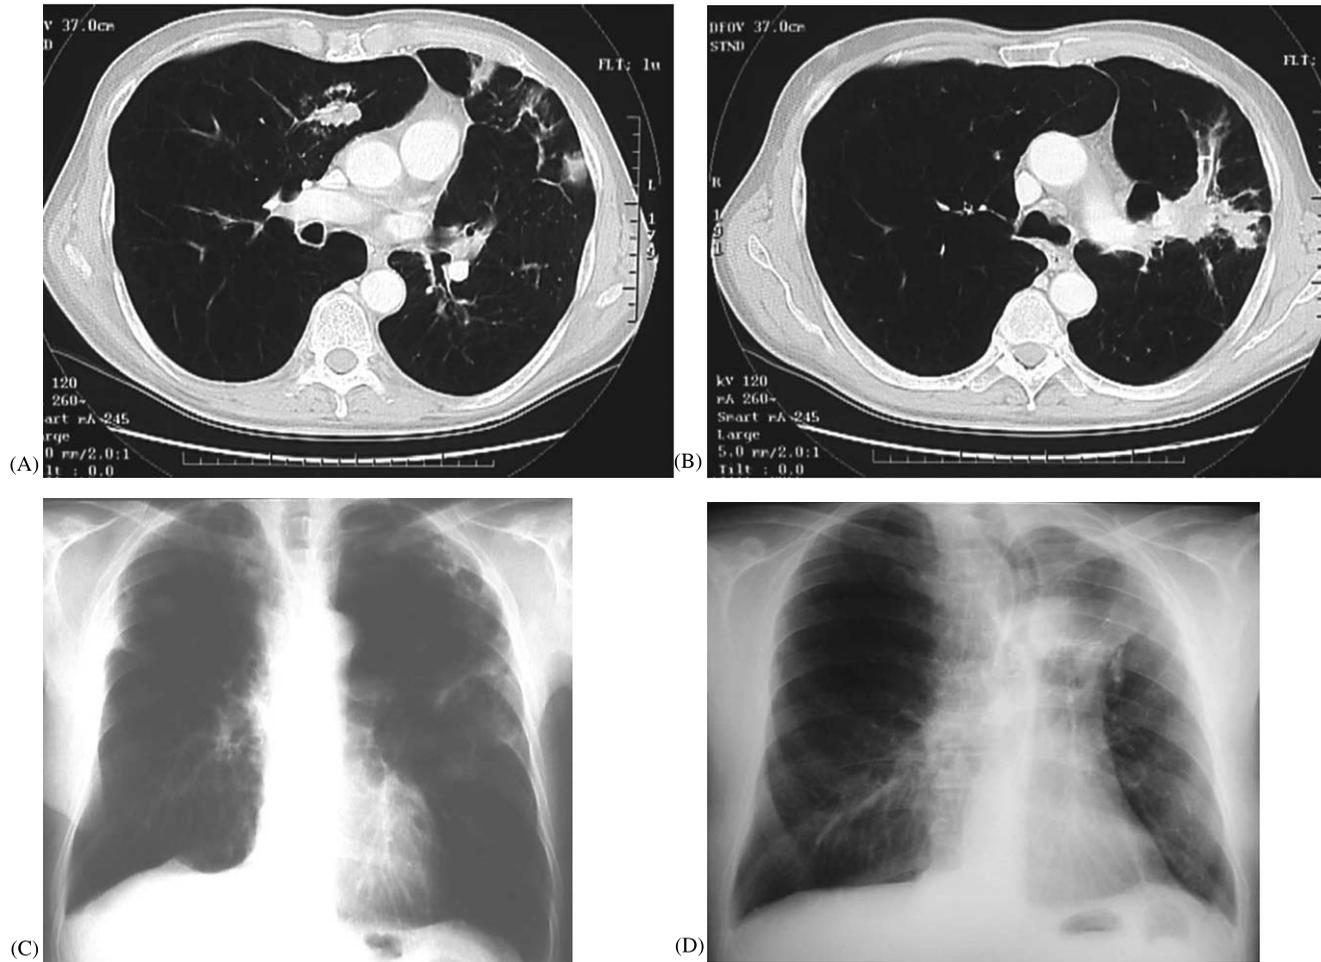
Case of a 61-year-old patient presenting with a bilateral tumour (middle lobe (A) and left upper lobe (B)) and a severe obstructive lung disease characterized by FEV1 of 0.98 l, FEV1% of 28.8%, DLCO% of 46.6% and residual volume (RV%) of 163.3%. The patient first underwent lung volume reduction surgery combined with a middle lobectomy for a pT2N0 adenocarcinoma and 2 months later a left upper lobectomy with sparing of the lingula (culminectomy) for a pT2N0 squamous cell carcinoma. Both the surgical outcomes were uneventful. At the latest follow-up, 2 years after the first resection, patient is well without evidence of relapse and spirometric tests improved as follow: FEV1 = 1.57 l, FEV% = 49%, TLCO% = 67% and RV% = 123.5%. Chest X-rays 1 month after right lung resection (C) and 18 months after left surgery (D) are presented.
